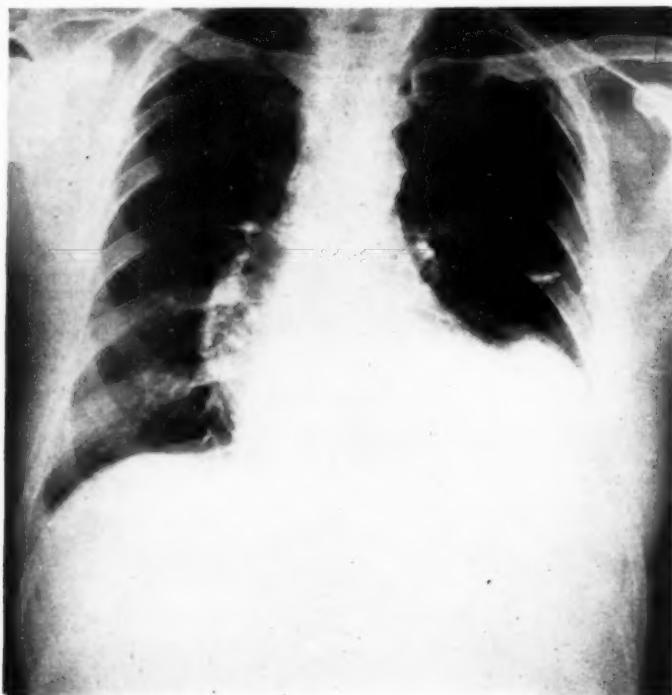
Chest roentgenogram of the first patient. A localized aneurysmal bulge is visible on the upper portion of the left ventricular contour.
